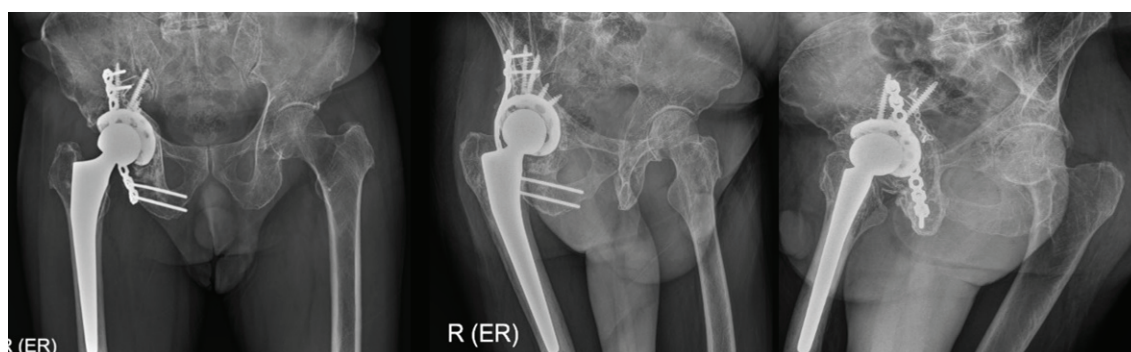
Right AP (left), obturator oblique (middle) and iliac oblique (right) post-operative radiographs at 2-year follow-up
